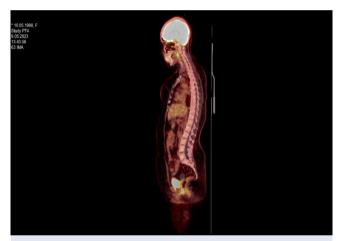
Positron emission tomography/computed tomography scan for neuroendocrine carcinoma-1.
